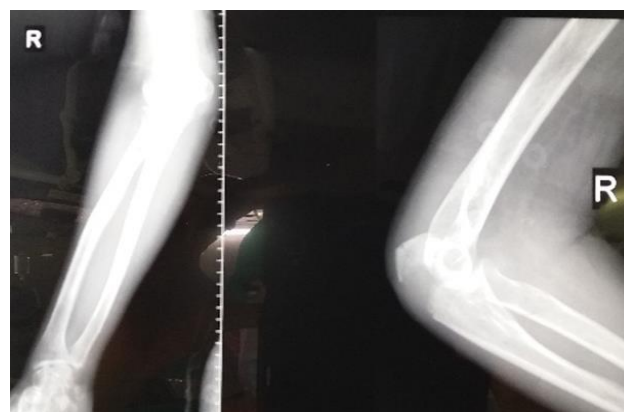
Pre-operative radiograph of olecranon fracture.
